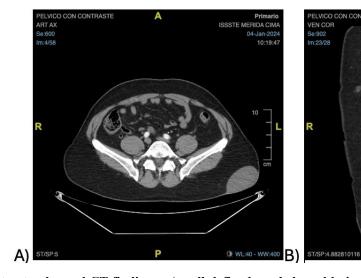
Contrast-enhanced CT findings. A well-defined, oval-shaped lesion with peripheral contrast uptake and irregular enhancement of the edges (suggesting chronic inflammation or capsular fibrosis) located in the subcutaneous tissue of the left lumbar region. A) Axial section view. B) Coronal section view.
